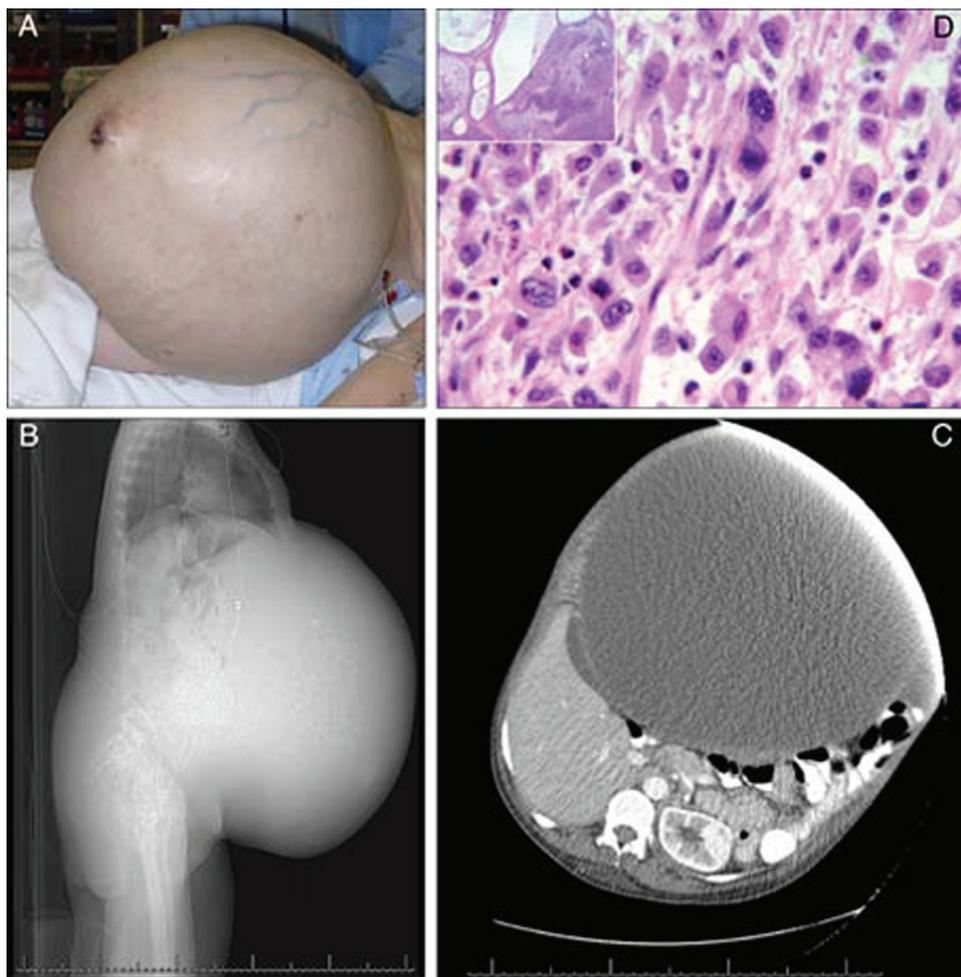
(A) Tumour protruding through her umbilical area that was oozing serosanguinous fluid. (B,C) CT of the abdomen revealing a large mass with loculated ascites. Multiple lung nodules were identified as well. (D) A poorly differentiated malignant neoplasm involving ovaries, the umbilical area and widespread omental metastases following tumour debulking.
